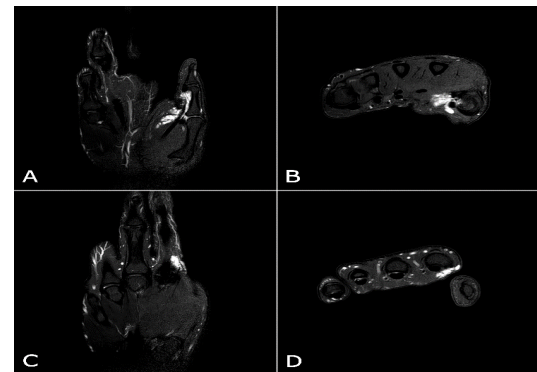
T2-weighted magnetic resonance images demonstrating a lobulated vascular malformation involving the volar aspect of the proximal phalanx of the thumb (A, B) and the radial side of the index finger (C, D).
